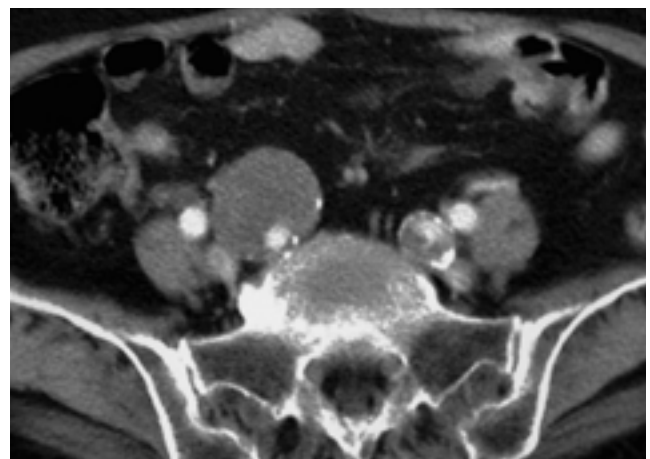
Abdominal CT scan shows aneurysms of both internal iliac arteries.
